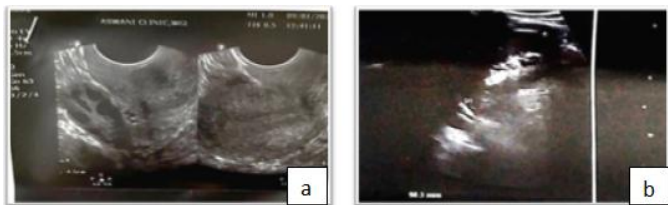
Ultrasonography a) Test group showing multiple follicles (pcos) b)Control group (non pcos , no evidence of multiple follicles)
